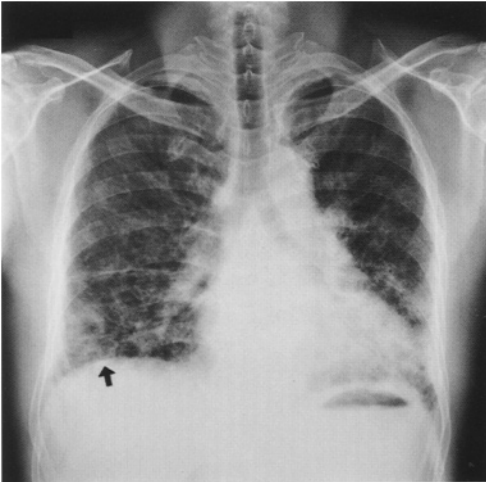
A PA chest radiograph reveals dense distribution of irregular opacities in both middle and lower lung fields. Diffuse pleural thickening is noted in both lower zones, a finding typical of asbestos-related pleural disease. A calcified plaque is visible on the right hemi-diaphragm (*arrow*). The ILO classification is 2/2, s/s, ih, pc, pt
